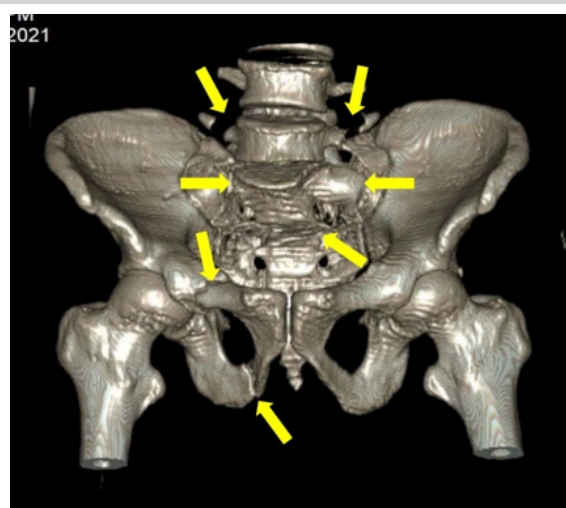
3D CT Reconstruction of the pelvis showing B/L transverse process fractures of L5, B/L sacral ala fractures, transverse fracture through S2 and S3, right superior and inferior pubic rami fractures
